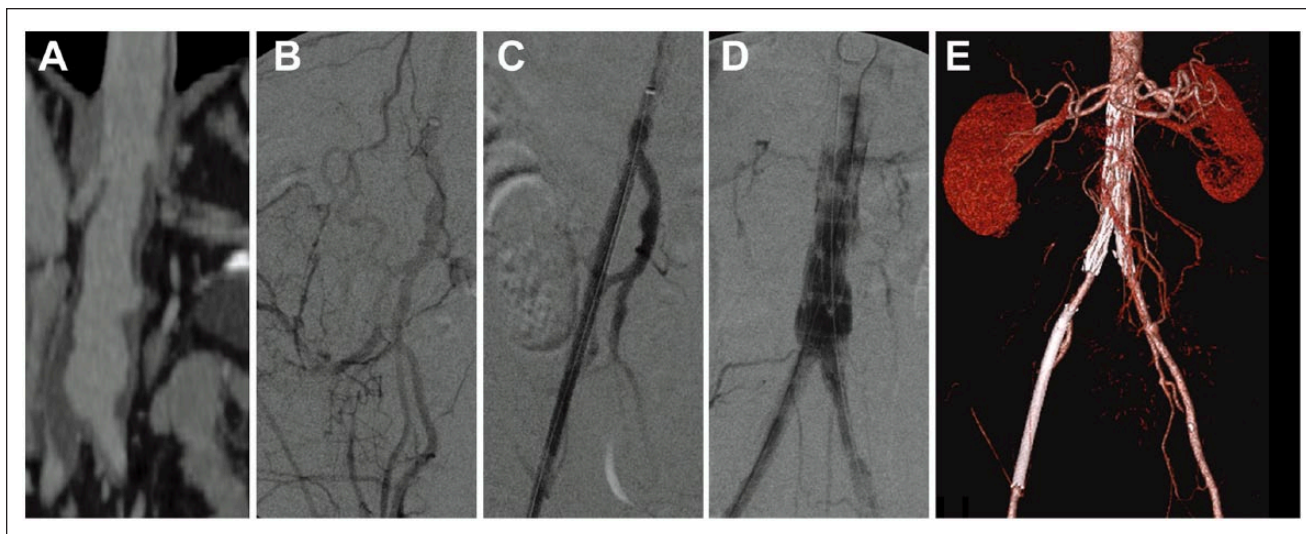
(A) Multiplanar reconstruction of preoperative computed tomography scan showing TransAtlantic Inter-Society Consensus D aortoiliac occlusive disease associated with abdominal aortic aneurysm. (B) Intraoperative angiography showing the long right external iliac artery occlusion (REIA) after ipsilateral common iliac artery (CIA) recanalization. (C) REIA recanalization and stenting, preserving the internal iliac artery. (D) Completion angiography showing AFX unibody stent-graft full expansion and complete AAA exclusion. (E) Volume rendering view from the 30-day computed tomography (CT), confirming complete AAA exclusion and patency of all treated vessels.
